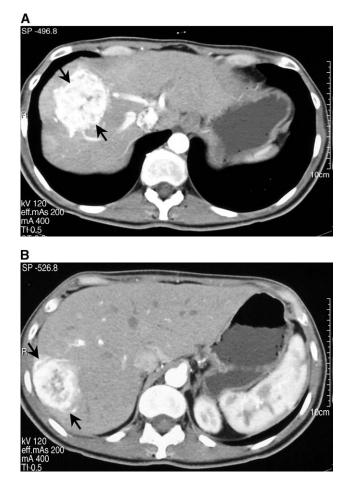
Computed tomographic scans performed before resection of liver metastases in patient (A)1. Lesion in segment 8. (B) Lesion in segment 7. Note the magnitude of the feeding veins into the liver, consistent with arteriovenous shunting.
